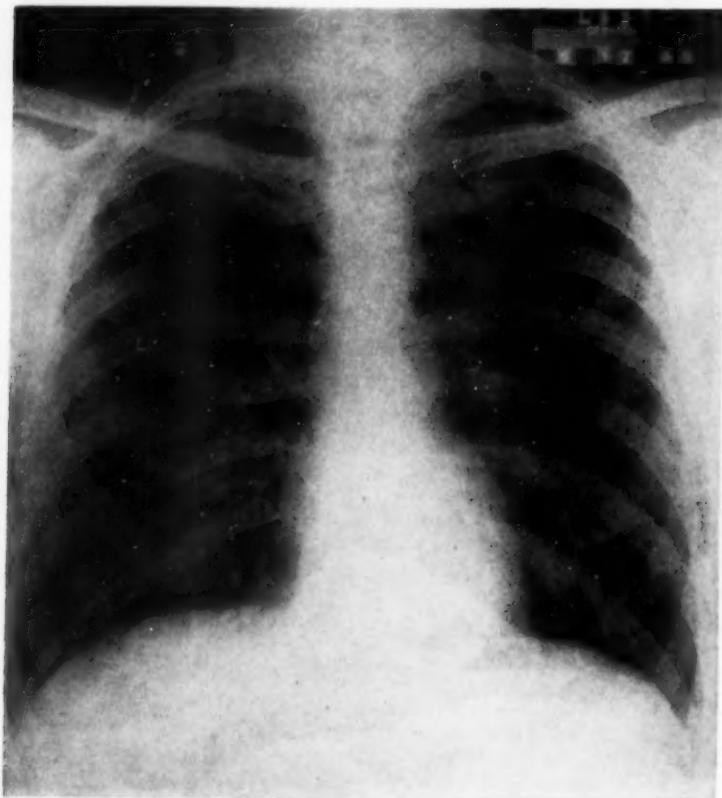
Normal radiograph, taken five months previous to that shown in figure 1.
